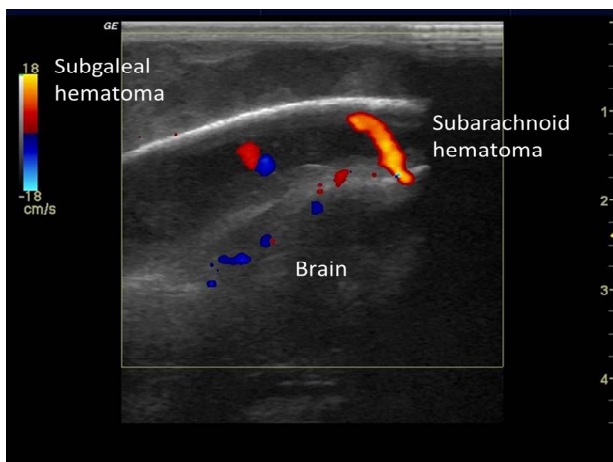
Image of ultrasound using 7 - 12 MHz linear probe. Color Doppler showed blood vessels crossing the hematoma area (cortical vein sign), confirming the hemorrhage in subarachnoid space.
